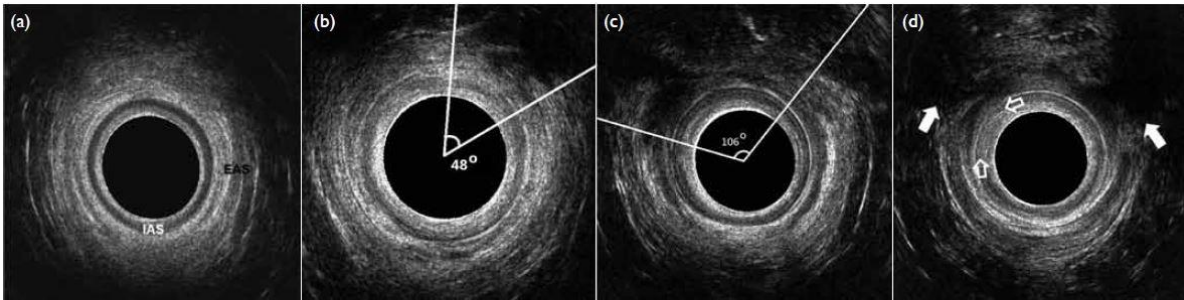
(a) Endoanal ultrasound of a 34-year-old woman after normal vaginal delivery. She was asymptomatic of anal incontinence. There was a complete hypoechoic ring (IAS) and mixed echogenic ring (EAS), signifying intact IAS and EAS with no OASIS. (b) Endoanal ultrasound of a 34-year-old woman after vacuum extraction. She was asymptomatic of anal incontinence. There was a hypoechoic defect of 48 degrees in the EAS involving less than half of the thickness of the EAS, indicating an occult partial-thickness EAS injury. The IAS was intact. (c) Endoanal ultrasound of a 29-year-old woman after vacuum extraction. She was diagnosed with a third degree (grade 3a) tear with repair done after delivery. A hypoechoic area in the EAS was present from 9 to 2 o'clock region (106 degrees) spanning the full thickness of the EAS; while the IAS was intact. She did not have symptoms of anal incontinence. (d) Endoanal ultrasound of a 30-year-old woman after normal vaginal delivery with occult anal sphincter injury. There was a hypoechoic area at 10 to 2 o'clock region (between solid arrows) involving full thickness of the EAS and a discontinuity in the hypoechoic ring which was the IAS at 9 to 11 o'clock (between arrow outlines), signifying both EAS and IAS injury. She was asymptomatic of anal incontinence. Abbreviations: EAS = external anal sphincter; IAS = internal anal sphincter; OASIS = obstetric anal sphincter injury
